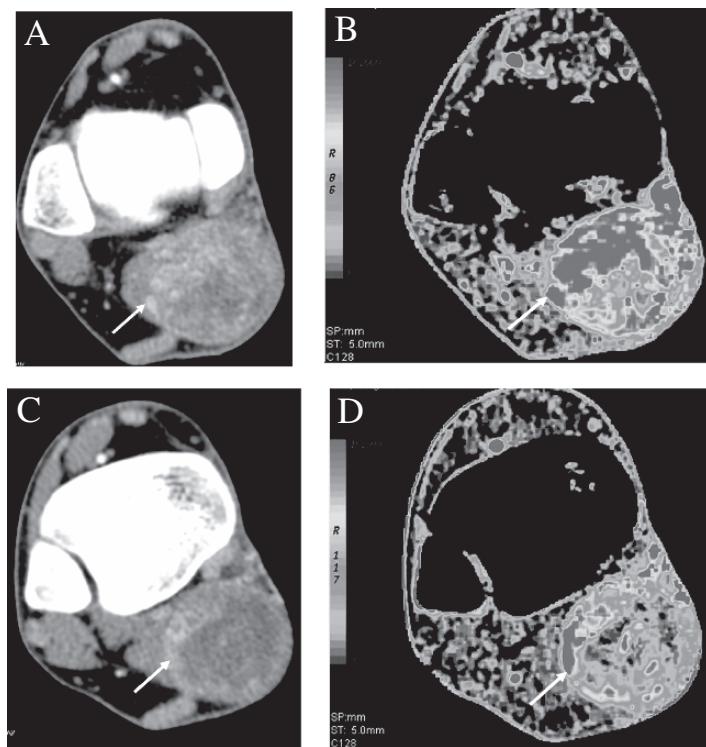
Thirty-one-year-old man with leiomyosarcoma of right ankle, undergoing treatment bevacizumab (anti-angiogenic drug). Serial contrast-enhanced CT (A = baseline, C = post-anti-angiogenic therapy) and corresponding blood volume maps (B, D, respectively) are shown. (A) Baseline contrast-enhanced CT demonstrates a heterogeneously enhancing mass (arrow) in the posterior aspect of right ankle with high tumor blood volume (arrow) seen on perfusion map (B). Follow-up imaging (C, D) performed after 2 weeks of initiation of bevacizumab therapy shows reduction in tumor tissue enhancement (C, arrow), with about 38% reduction in tumor blood volume (D, arrow). (Please see color insert.)
